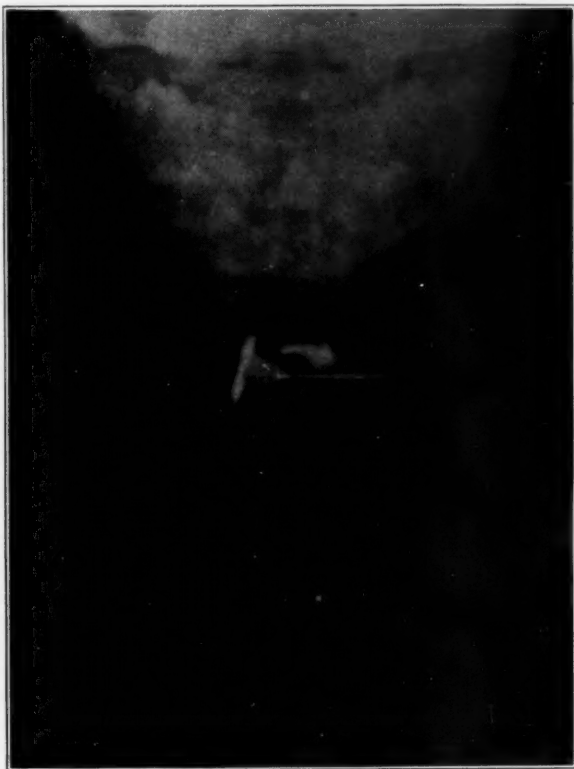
Roentgenogram taken after injection of iodized poppyseed oil, showing block at the level of the first dorsal vertebra.
